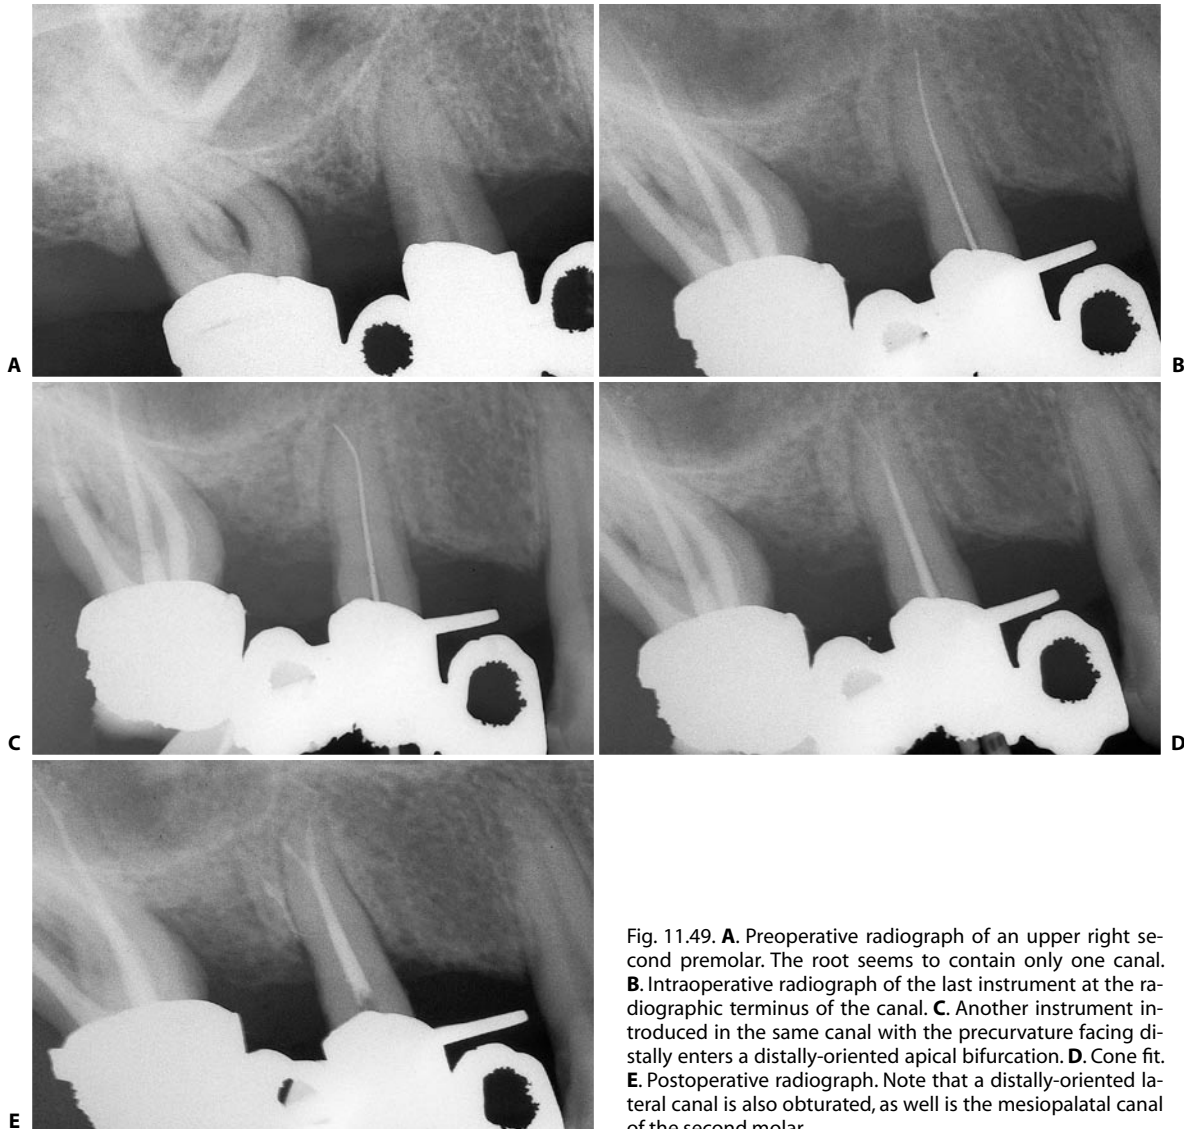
A. Preoperative radiograph of an upper right second premolar. The root seems to contain only one canal. B. Intraoperative radiograph of the last instrument at the radiographic terminus of the canal. C. Another instrument introduced in the same canal with the precurvature facing distally enters a distally-oriented apical bifurcation. D. Cone fit. E. Postoperative radiograph. Note that a distally-oriented lateral canal is also obturated, as well is the mesiopalatal canal of the second molar.
